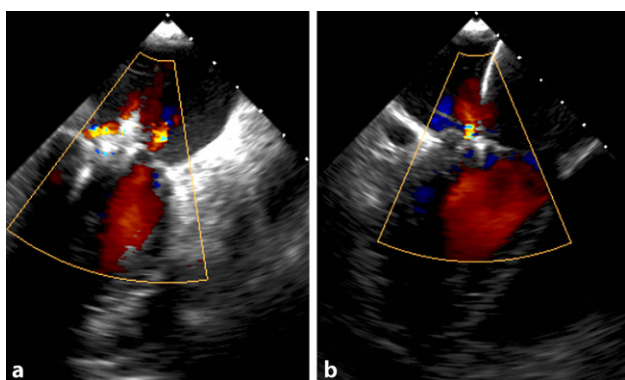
Transesophageal echocardiography with color Doppler flow of the final result after the second MitraClip procedure in patient no. 4 showing captured both mitral valve leaflets and trace residual mitral regurgitation (a intercommissural view, b long axis view)
